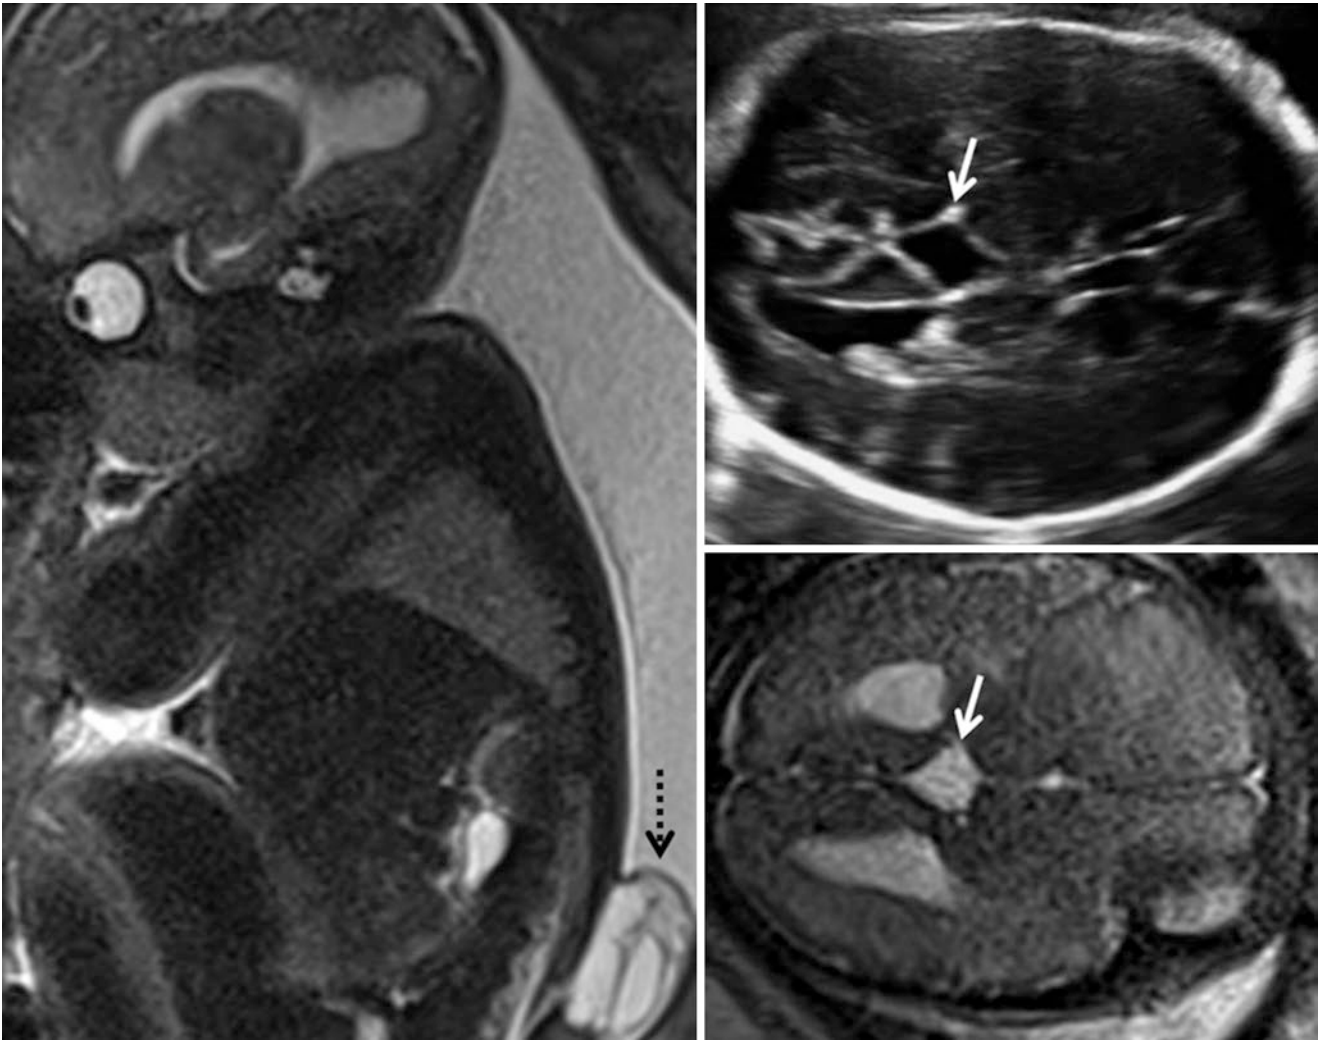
32 weeks (TAS and MRI) *diamond sign* in a case of lumbosacral open spina bifida – ‘diamond’ sign (solid arrow), lumbosacral myelomeningocele (dotted arrow)
